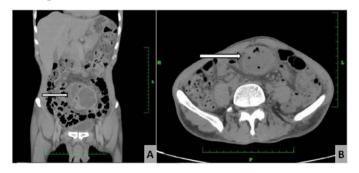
& 1B: Contrast enhanced computed tomography (CECT) abdomen showing a cystic swelling in the pre-peritoneal region (arrow).
